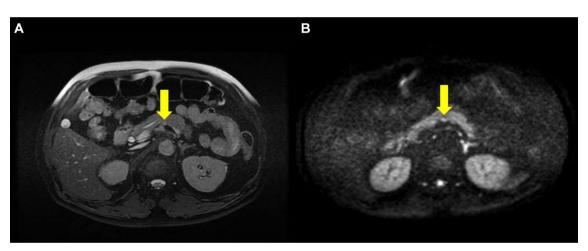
a MRI taken 3 years after follow-up. T2-weighted image showed a 9-mm high-intensity mass in the pancreas body (arrow). b Diffusion-weighted images showed slightly high intensity at the same site (arrow). The tumor has not changed significantly after 3 years of follow-up
